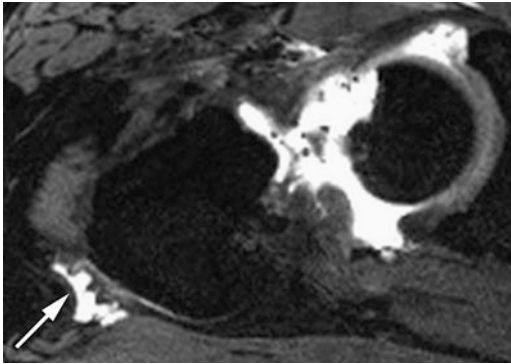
T2-weighted axial 3D sequence at saturated axial TSE sequence of a 47-year-old male patient (TR 11.3 ms/TE 4.9 ms, slice thickness 0.7 mm) demonstrates also a bursitis trochanterica (*arrow*) in a 47-year-old female patient
